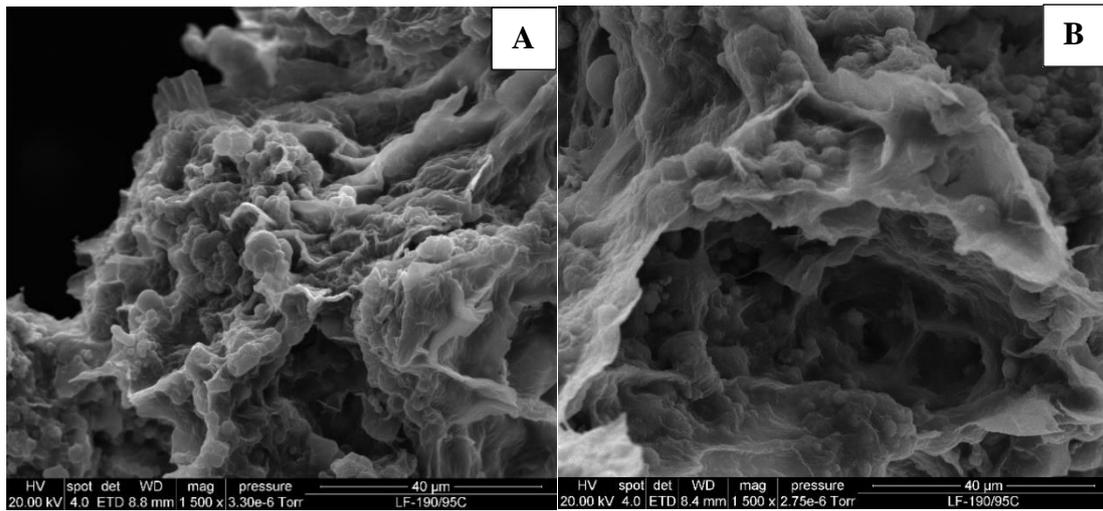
SEM images of the spent HSMs obtained by extraction at 65 °C and pH 9 (A) untreated sample (B) ultrasound treated at 80% amplitude.
